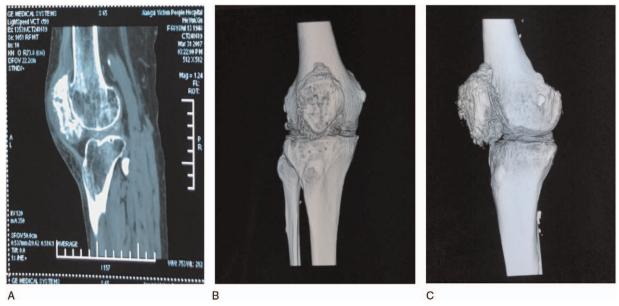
(A) CT: irregular lytic lesions on the patella. (B, C) Three-dimensional CT reconstruction: a few lytic lesions on the patella, resulting in rugged surface and edges.
